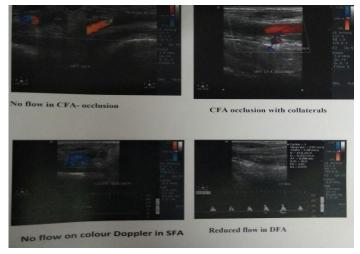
Doppler ultrasound images reveal varying degrees of stenosis in different patients.
